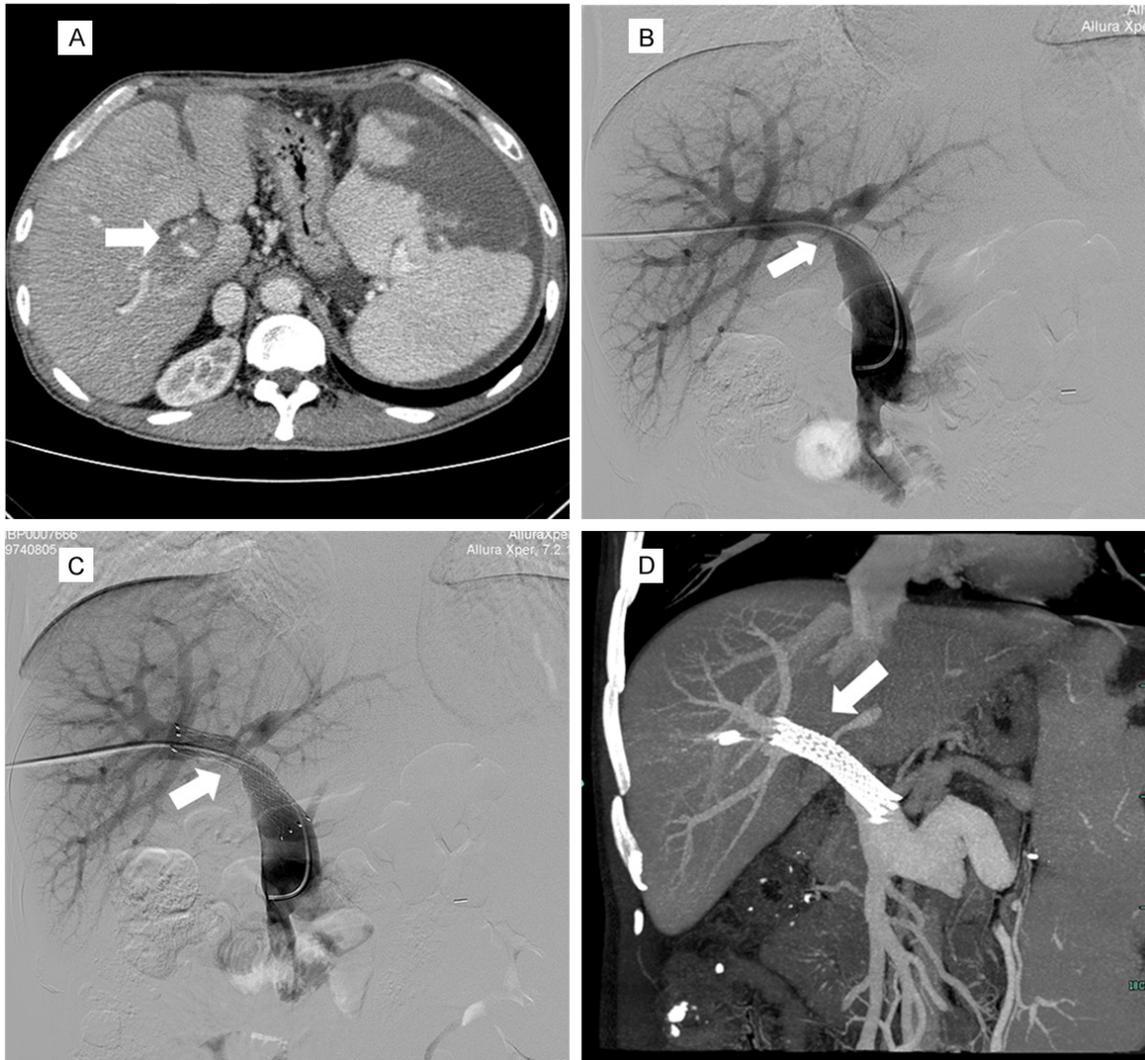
A 39-year-old male patient demonstrated main PV stenosis at 50 days after LT. A. Enhanced computed tomography showed that periportal fibrosis at porta hepatis(arrow) seemed to have led to PVS. B. Before stent placement, transhepatic portography also revealed a PVS at porta hepatis(arrow). C. Portal venogram obtained immediately after metallic stent placement (arrow) displayed no further PVS. D. The follow-up abdominal CTA showed patency of the metallic stent (arrow) in the portal vein of the liver graft. PV = portal vein, LT = liver transplantation, PVS = portal vein stenosis, CTA = computed tomography angiography.
